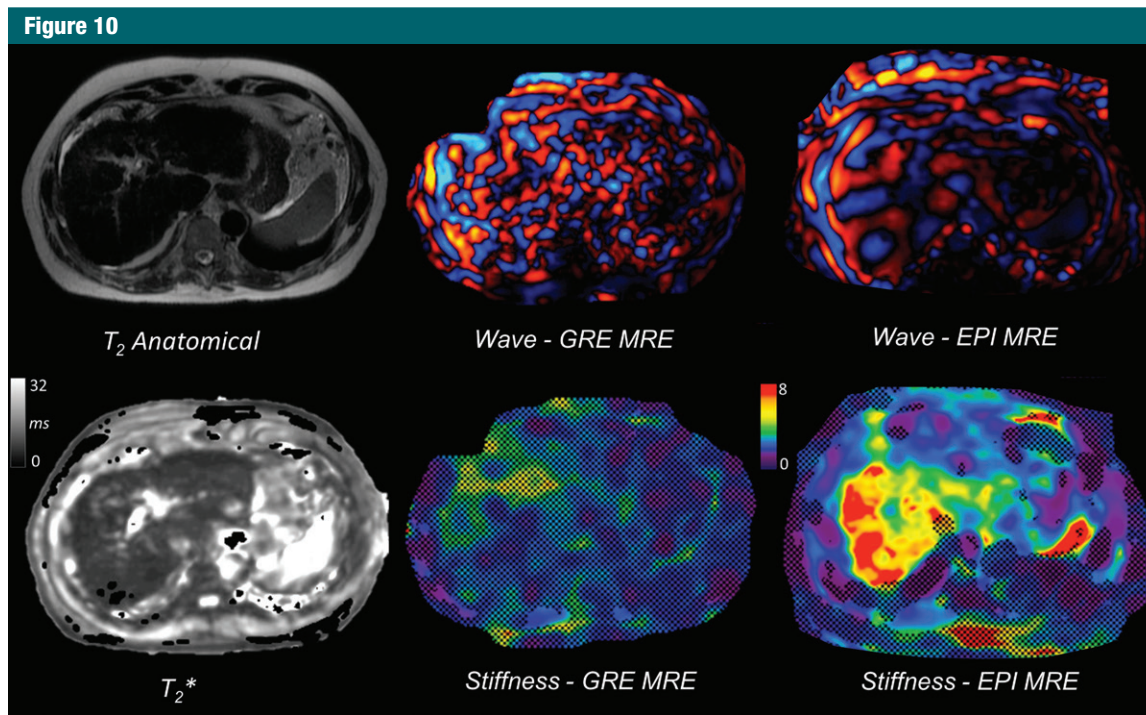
Images in a 61-year-old man with cirrhosis secondary to chronic hepatitis C virus infection and secondary hemosiderosis causing failure of two-dimensional gradient-recalled-echo (GRE) MR elastography (MRE) at 1.5 T. The shortened liver T₂* (4.7 msec) due to iron deposition causes low signal-to-noise ratio, with disorganized wave propagation pattern and no areas of reliable stiffness measurement. Two-dimensional echo-planar imaging (EPI) sequence performed during the same MR imaging examination is less sensitive to T₂* effects, allowing successful wave propagation and liver stiffness measurement (5.6 kPa).
